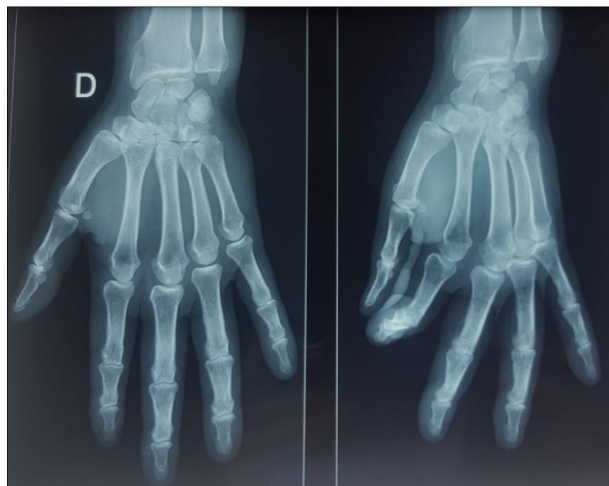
The normal hands and wrists x-ray.
